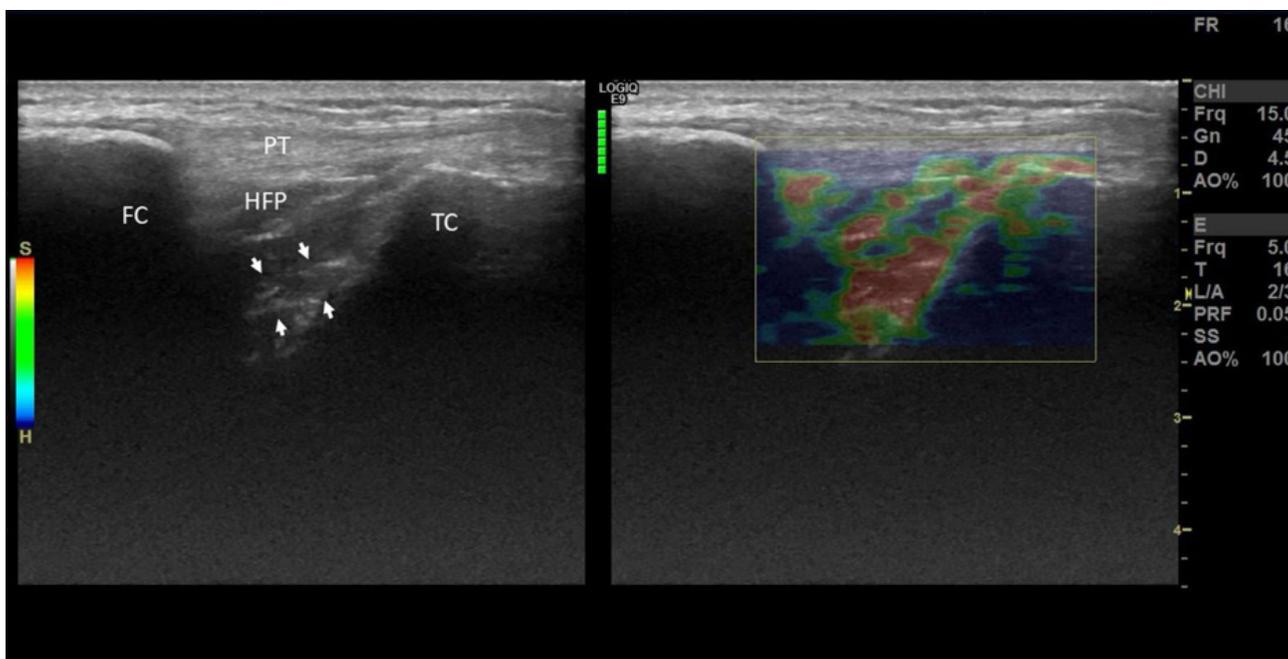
Preoperative longitudinal B-mode grayscale ultrasound and strain elastography images of the anterior cruciate ligament (FC: femoral condyle, TC: tibial condyle, PT: patellar tendon, HFP: Hoffa's fat pad).
